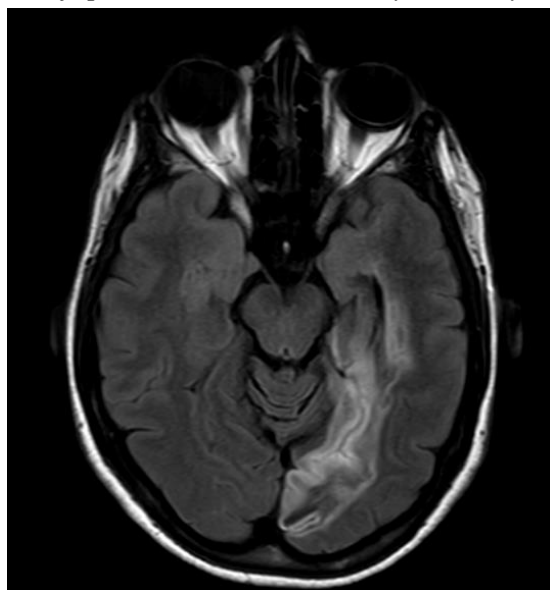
MR Head: Axial FLAIR view showing hyper-intensity in the left posterior cerebral artery territory indicative of an acute ischaemic stroke.
